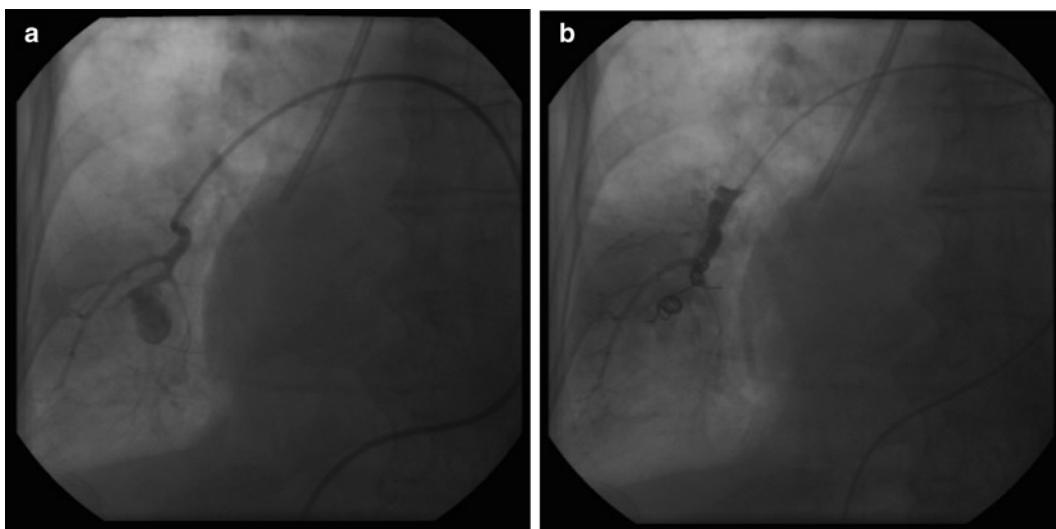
(a) Radiographic contrast dye injection showing a false aneurysm of the pulmonary artery of the right lower lobe following massive hemoptysis induced by pulmonary artery catheter rupture. (b) A coil has been placed by interventional radiology in the false aneurysm of the right lower pulmonary artery in the same patient. Dye injection shows that the aneurysm has embolized with no further leakage.
